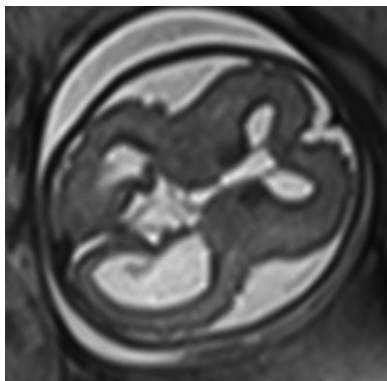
T2-weighted axial image, gestational age 27 weeks, showing severe ventriculomegaly, megalencephaly (> P97) and polymicrogyria, the latter characterized by the spicular, irregular outlining of the cerebral surface. Tentative diagnosis of MPPH (megalencephaly – perisylvian polymicrogyria - post-axial polydactyly - hydrocephalus) syndrome based on the additional finding of bilateral post-axial polydactyly.
